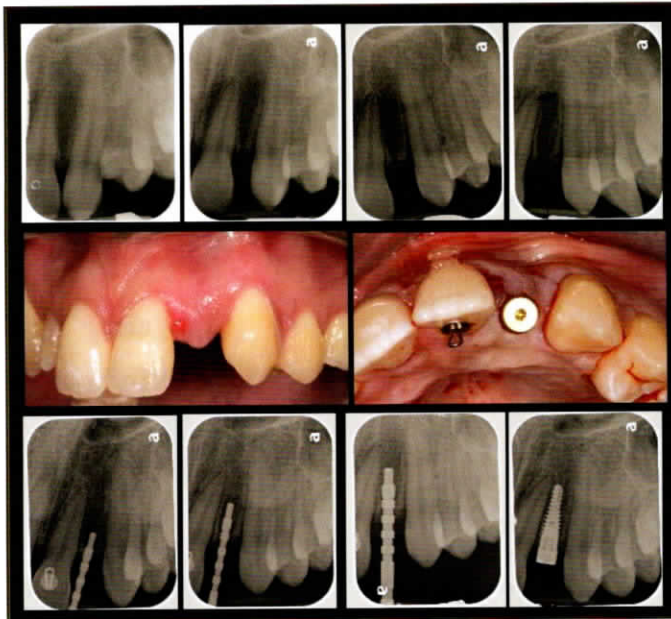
creation of sufficient space and placement of implant #10. Note the importance of radiographic monitoring as the space develops. Merely relying upon clinical crown position can often be misleading.
